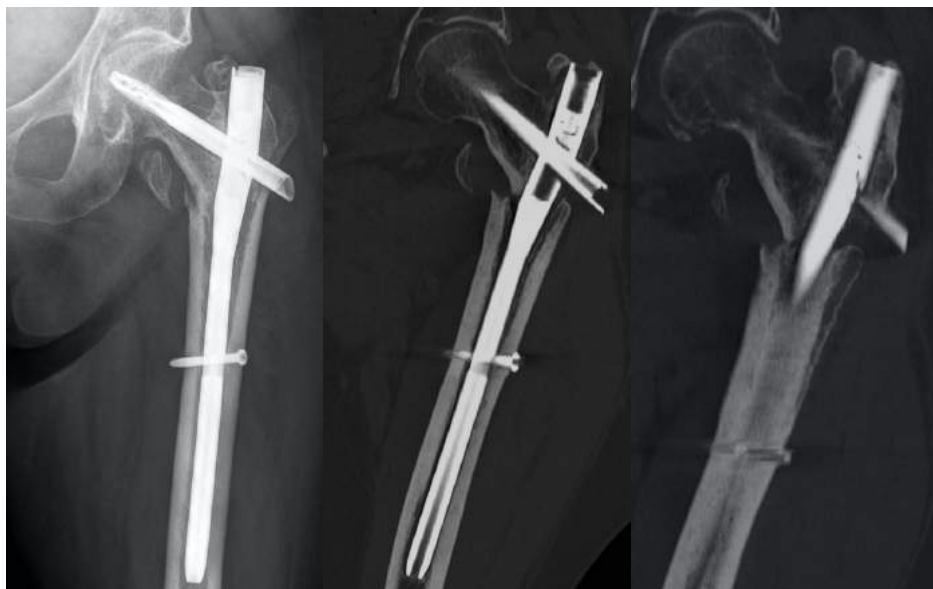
X-ray and CT of Case 1
